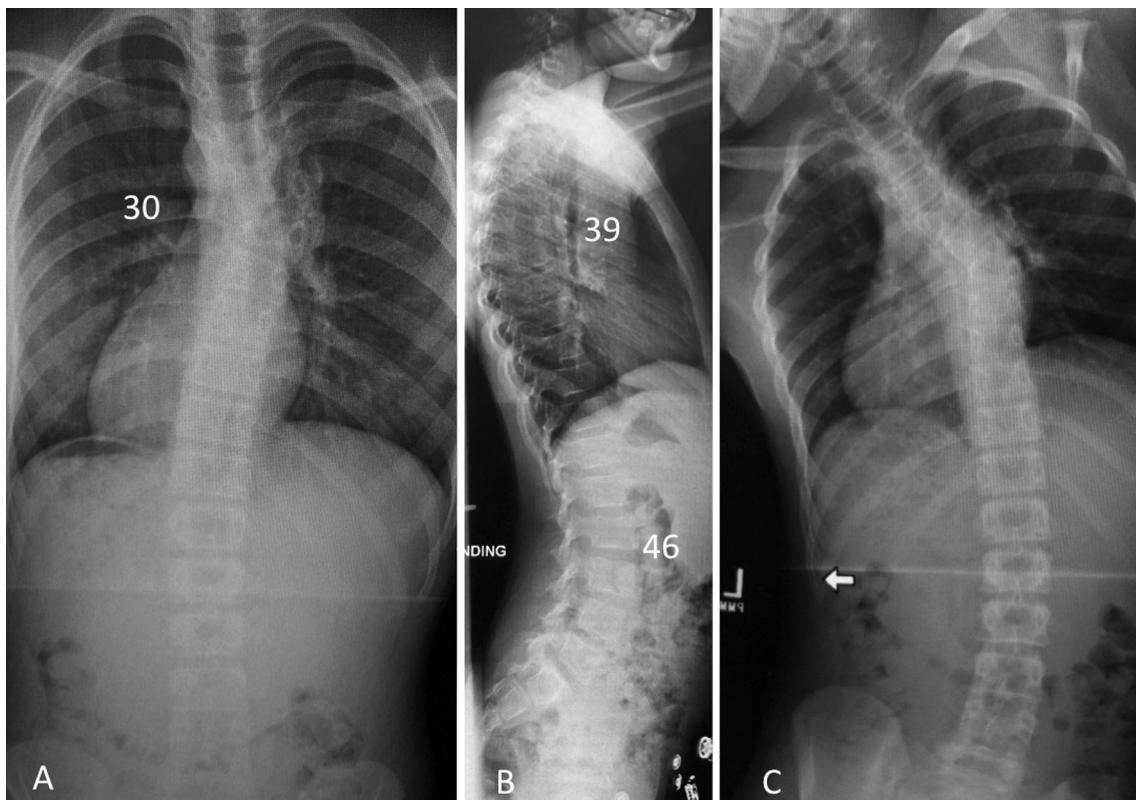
Standing AP and lateral radiographs a, b showed right thoracic scoliosis of 30° due to hemivertebrae at T7 level on the *right side* with normal thoracic kyphosis and lumbar lordosis. *Left-side bending* c showed hemivertebrae at right T7 level
